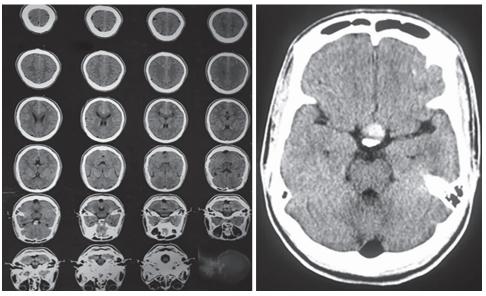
Noncontrast computed tomography scan highlighting the lesion
